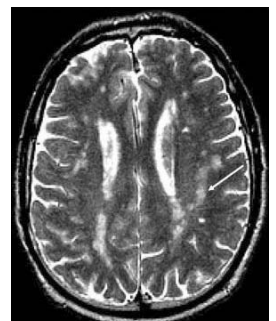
Intermediates phenotypes used in stroke genetic research. A. Common carotid artery intima-media thickness on the posterior wall of the artery. IMT (arrowed) includes the inner bright line and the dark line deep to this. B. White matter hyperintensities (one arrowed) on a T2 weighted MRI scan. Recent data¹⁶ suggest that confluent WMH progress and appear to represent small vessel cerebrovascular disease. (copyright with author-HM).
